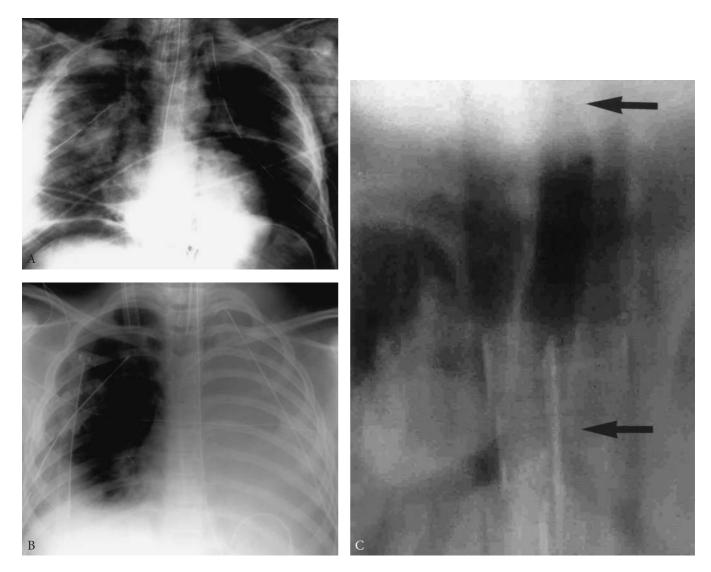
Example of complex tracheobronchial injury in an 8-year-old girl, thrown from a vehicle and crushed as it rolled over. A, Initial chest roentgenogram. Bilateral pneumothoraces (intubated) and extensive emphysematous dissection of chest wall muscles and planes. There is little evidence of rib fractures or displacement, due to flexibility of the rib cage in childhood. At the initial hospital, laparotomy was negative. Tracheal transection was identified and presumptive repair was done under cardiopulmonary bypass. B, Subsequent chest film shows complete opacification of the left chest. Eight days after injury, she was urgently transferred. The initial repair was found to be inadvertent anastomosis of trachea to right main bronchus rather than to trachea. The concurrent rupture of the left main bronchus went unrecognized. At right thoracotomy, the tracheobronchial repair and right hilum were mobilized intrapericardially. The left bronchial stump could not be freed under the aortic arch because of inflammation and early scar formation. This required mobilization via left thoracotomy. Left intrapericardial mobilization was also done and the aortic arch was freed. Finally, via sternotomy and transpericardial dissection between the vena cava and aorta, and after proximal tracheal mobilization, it was possible to implant the debrided left main bronchus in the left lateral wall of trachea above the prior anastomosis. A second anesthesia machine was used to reinflate the left lung prior to anastomosis, vastly improving oxygenation. If the pathologic findings after 8 days could have been anticipated, alternative incisions might have been possible. C, Tomogram showing final reconstruction. The upper arrow marks the glottic level. In the neocarina, the right main bronchus appears long due to deviation of the distal trachea to the right, below the left bronchial anastomosis (lower arrow). The patient's further course was excellent.
